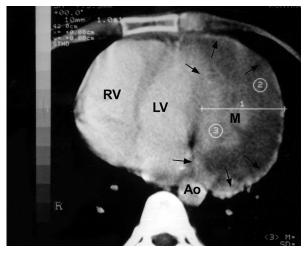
Helical computed tomography shows, at the patient's left, a mass that is mostly cystic at its caudal end. It lies adjacent to the great vessels and the left ventricle. The arrows delineate the borders of the mass.
